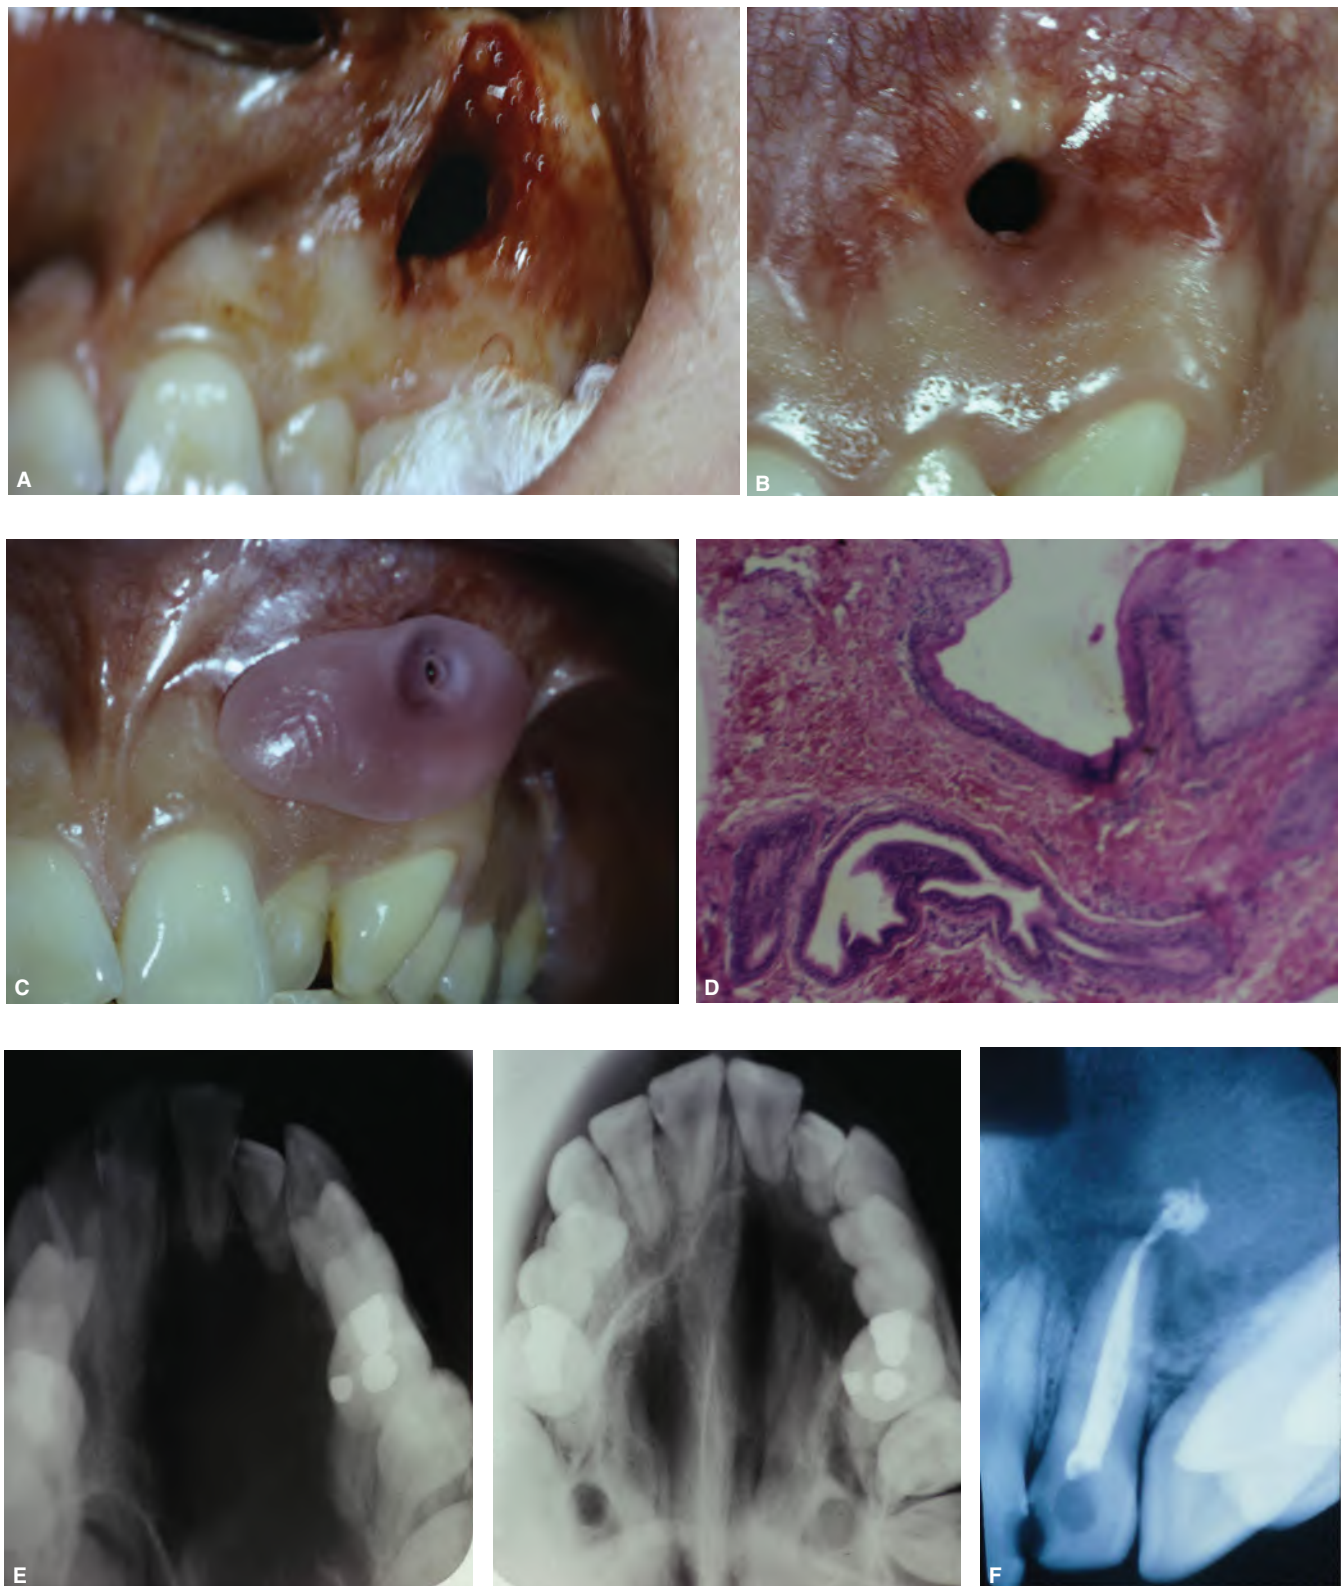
Decompression procedure. A. Surgical window into cyst. B. Healed surgical window. C. Acrylic stint in place. D. Biopsy from window consistent with radicular cyst. E. Palatal radiographs showing loss of bone on left and bone fill after 3 months of decompression (right). F. Maxillary left lateral incisor obturated after 3 months of decompression. (Courtesy of J. Craig Baumgartner, Kailua, HI, U.S.A.)
